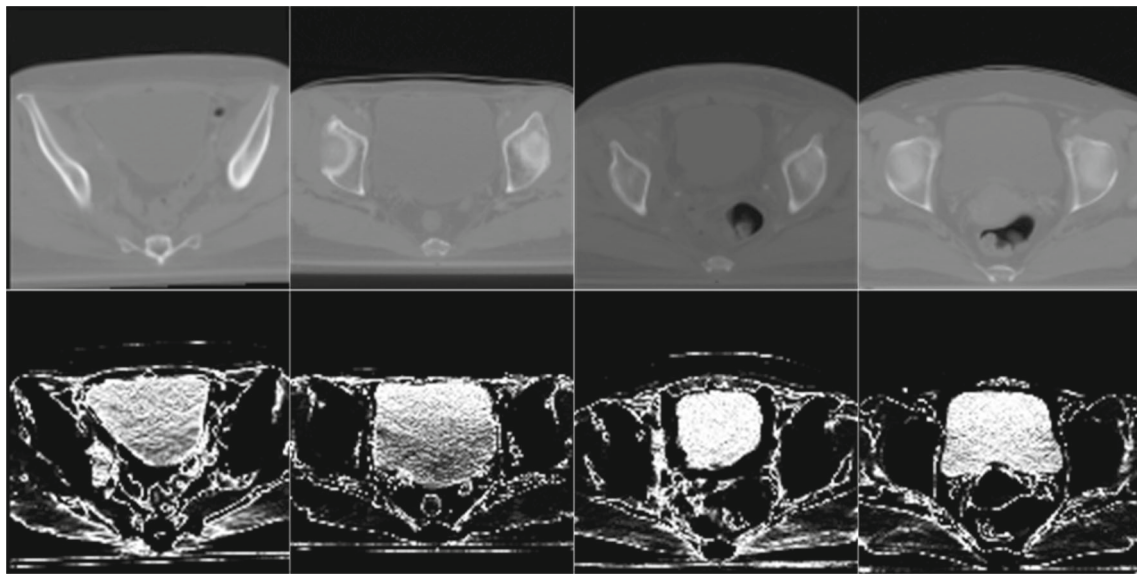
Original CT images (first row) and enhanced bladder density maps (second row)
